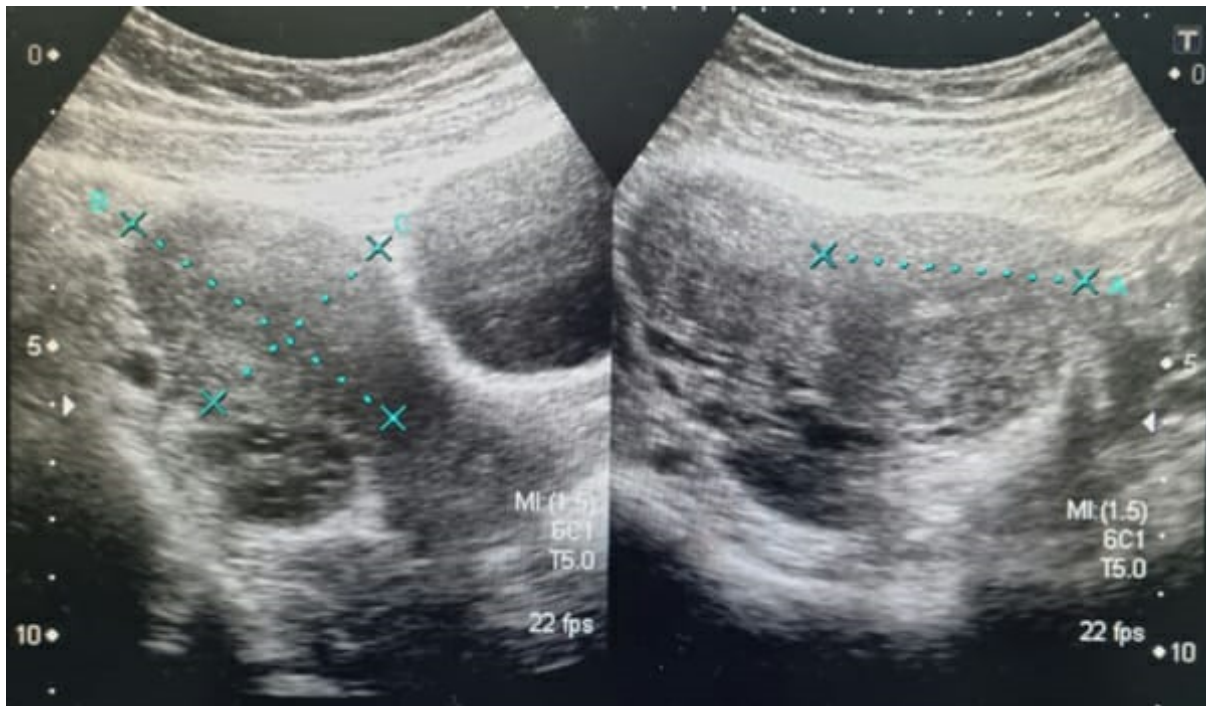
Abdominal ultrasound showing right ectopic with a small fibroid.
